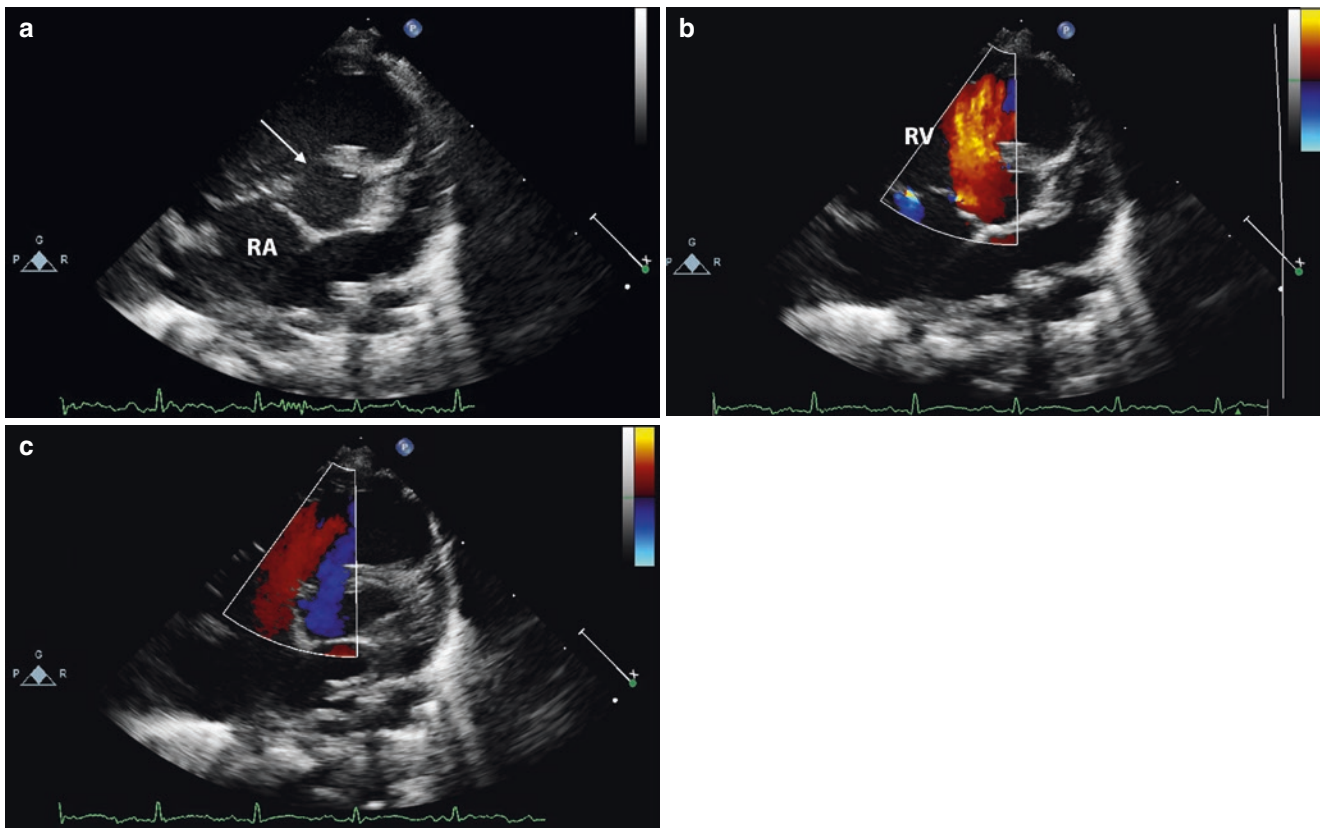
Large perimembranous VSD (*arrow*) in the parasternal short-axis view (a). Colour Doppler displays LR-shunting during systole (b) and some RL-shunting in diastole (c). RA right atrium, RV right ventricle
